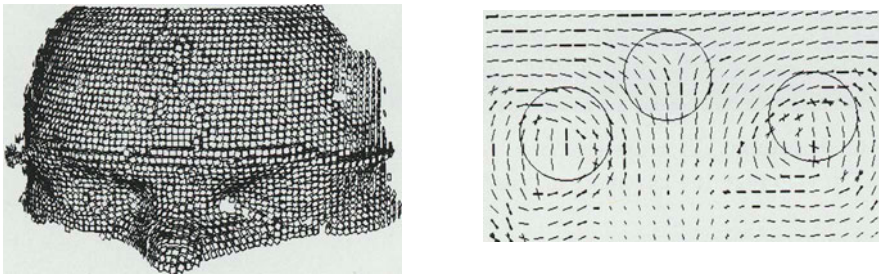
Computation of umbilic points on the MR image of a human face. (a) Tangent planes. (b) Principal direction field showing three typical singularities at umbilic points.
